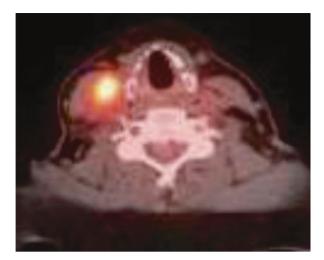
Axial cut fused PET/CT shows node with increased SUV on the right side adjacent to the external thyroid cartilage of the larynx
